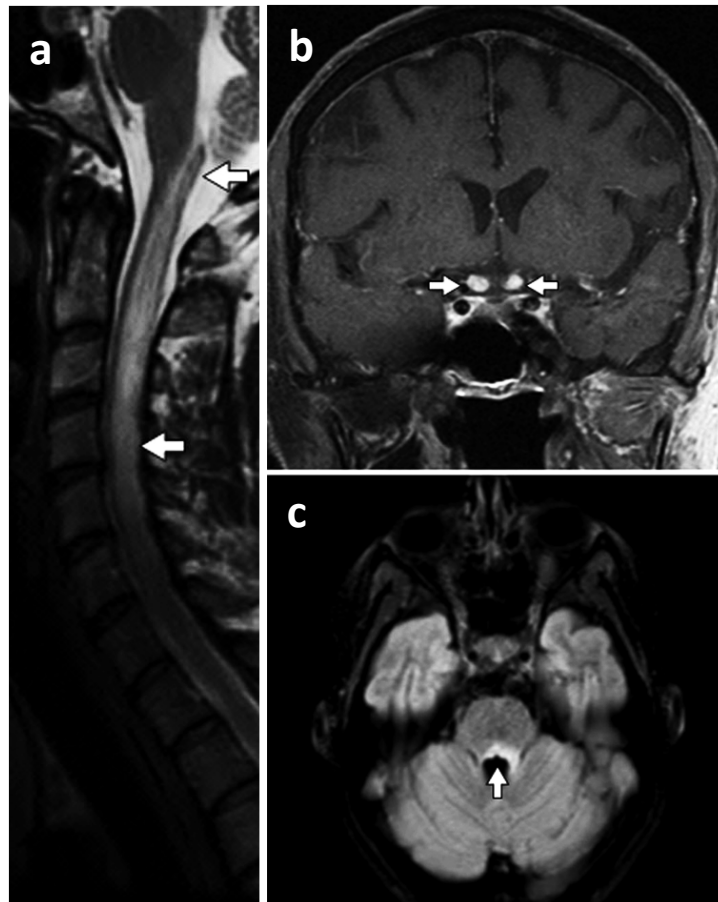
Representative magnetic resonance images (MRIs) of NMO patients: Sagittal T2-weighted images of the cervical spine with a typical longitudinally extensive lesion over more than three vertebral segments and extending into the brainstem (a) with arrows indicating the borders of the lesion; bilateral optic nerve enhancement (b, arrows); signal abnormality next to the fourth ventricle in the region of the area postrema (c, arrow) (Flanagan & Weinshenker 2014)
